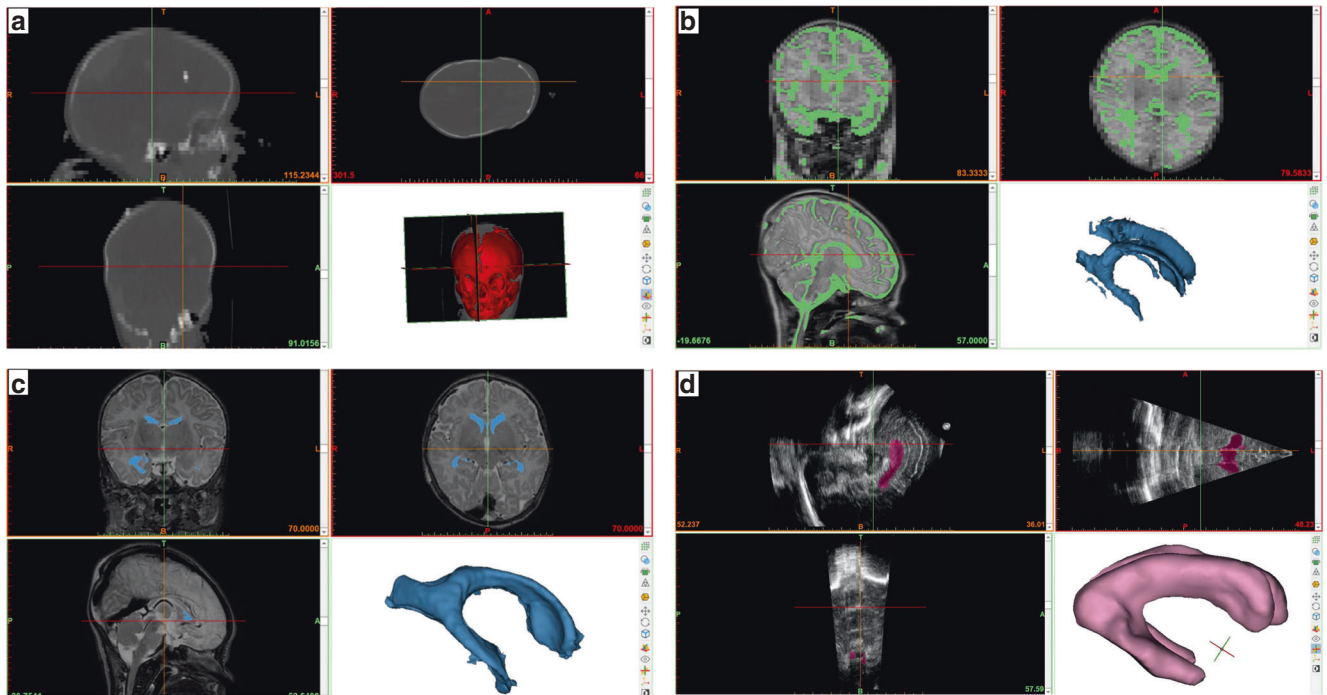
Digital neonatal head and ventricular system models based on the segmentation of different imaging protocols directly after contrast segmentation and before refinement and reconstruction of the segmentation. a Segmented CT-based skull model, b segmented T1-weighted 3D MRI-based ventricular model, c segmented T2-weighted isovoxel 3D MRI-based ventricular model, d segmented 3D ultrasound-based ventricular model.
